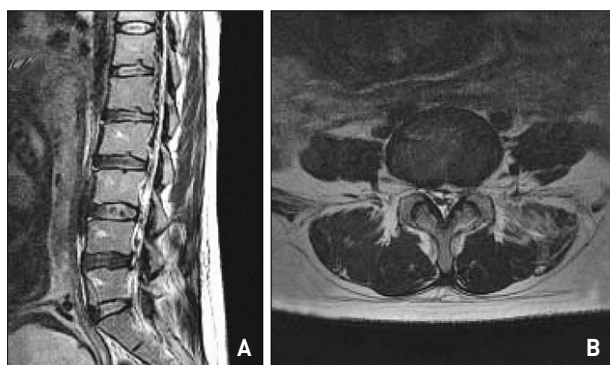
A : Postoperative sagittal and axial T2 weighted magnetic resonance images revealing well-removed lesional disc.
